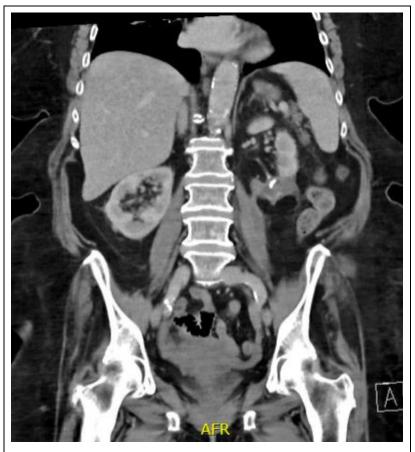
CT abdomen and pelvis with contrast post drainage of collection once again demonstrating proximity of colon to lower pole XGPN.
